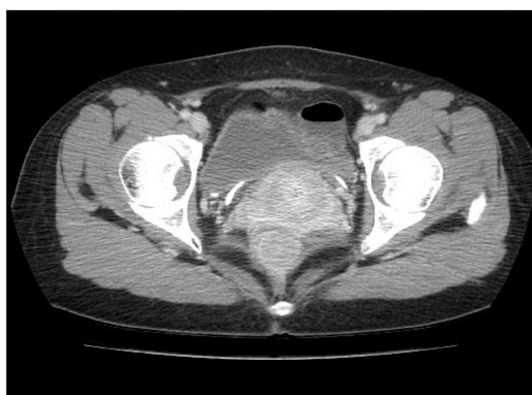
Pre-operative CT imaging. Well-defined and homogenous mass in rectum.
